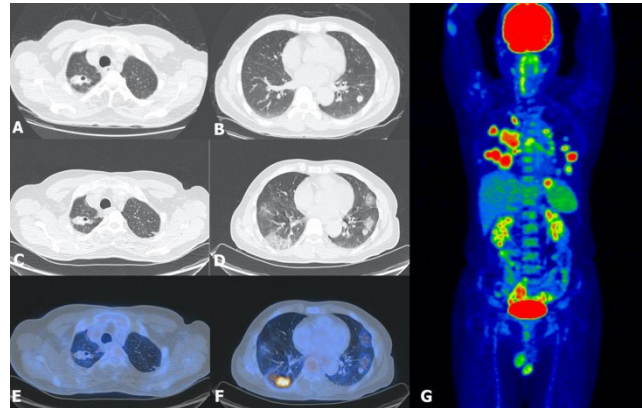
(A and B) A cavitory nodule and scar in the right upper lobe representative of old tuberculosis in addition to a 15mm parenchymal nodule in LUL in the initial chest CT scan, 6 May 2020. (C, D, E, F, and G) FDG PET/CT shows low-grade metabolic activity in the mentioned pulmonary nodule in addition to multifocal hypermetabolic ground glass opacities throughout both lung fields, 17 May 2020
